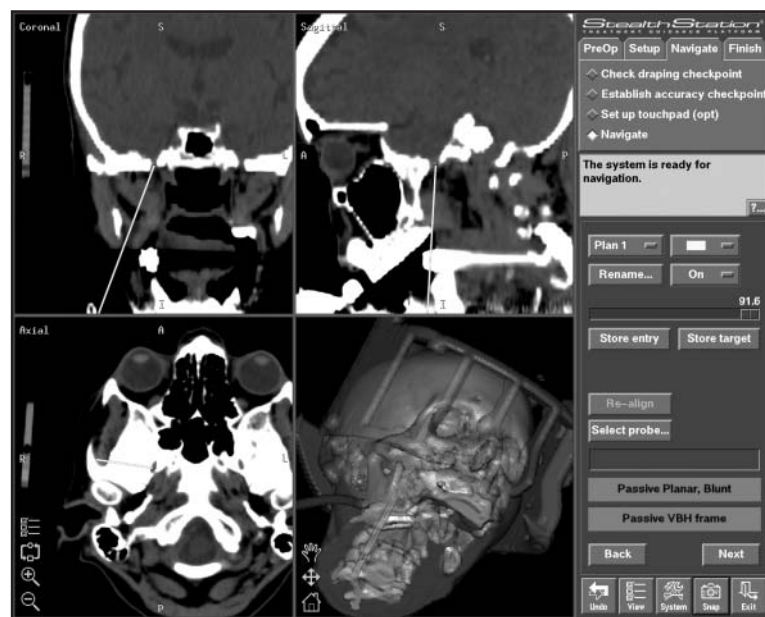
Electrocoagulation of the Gasserian ganglion: determination of path through the foramen ovale on the navigation system based on pre-operative CT data.
